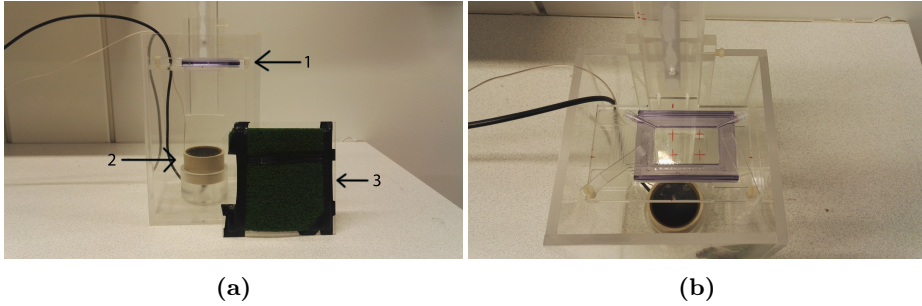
Front (a) and top (b) view of the experimental setup, with the plexiglass tank that was filled with water. 1) Sample holder with the CLINICell (purple) mounted in place; 2) Ultrasound transducer; 3) Absorbing lid.
